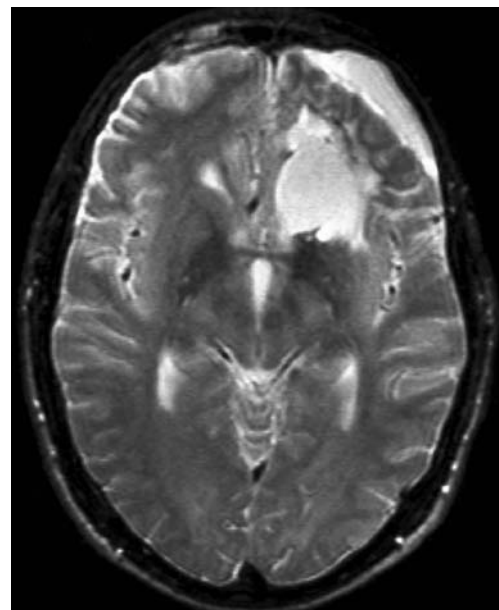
One-year follow-up MRI (T2-WI) of Patient 1 with CSF-filled resection site and left subdural hygroma; no tumour rest or spilled components
